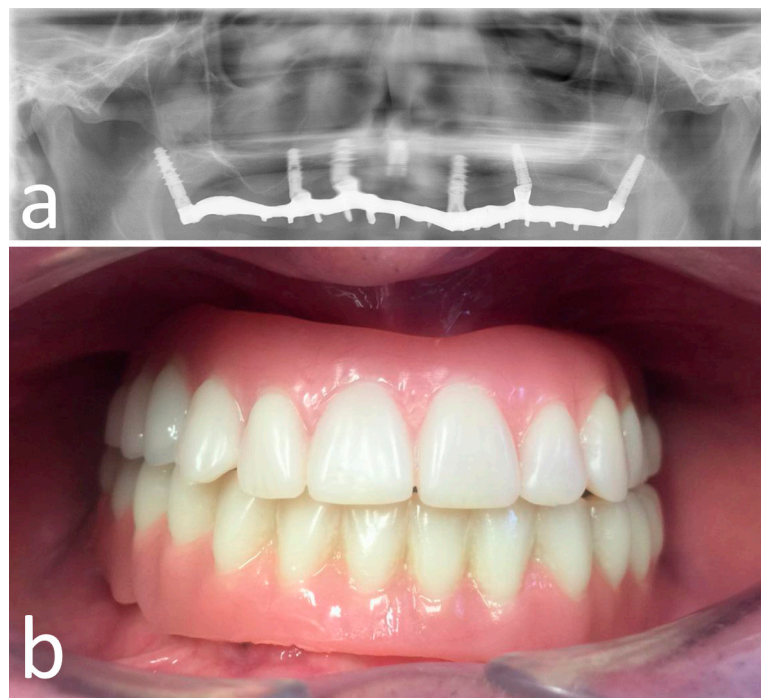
Opt X-ray (a) and clinical (b) view of the provisional prosthesis realized using conventional straight and angled multi-unit abutment (M.U.A.).
